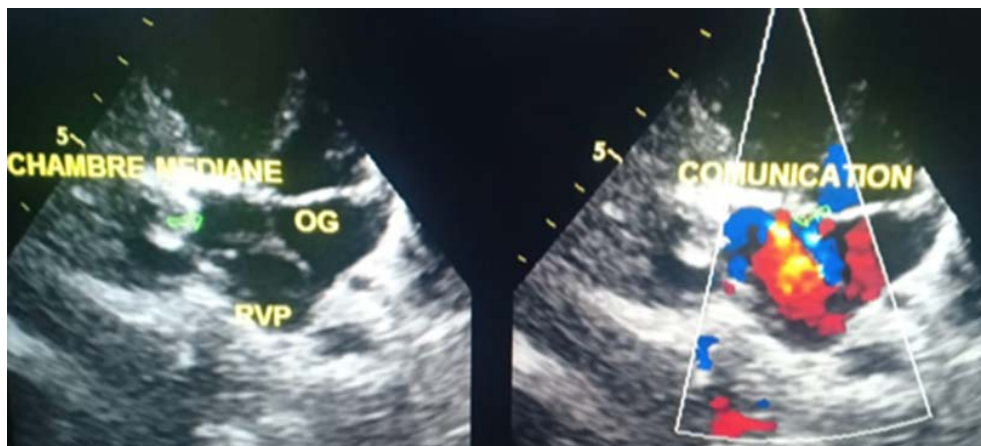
Transthoracic echocardiography: Apical section showing a triatrial sinistum heart with a severe obstruction between the pulmonary veins and the left atrium in color Doppler (OG: Left ventricle, RVP: pulmonary venous return)
